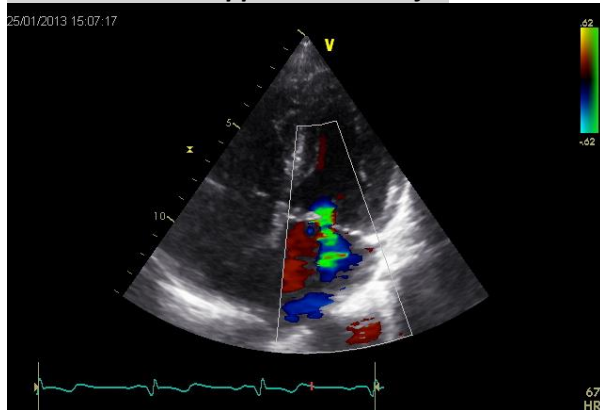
Color Doppler of mitral valve
